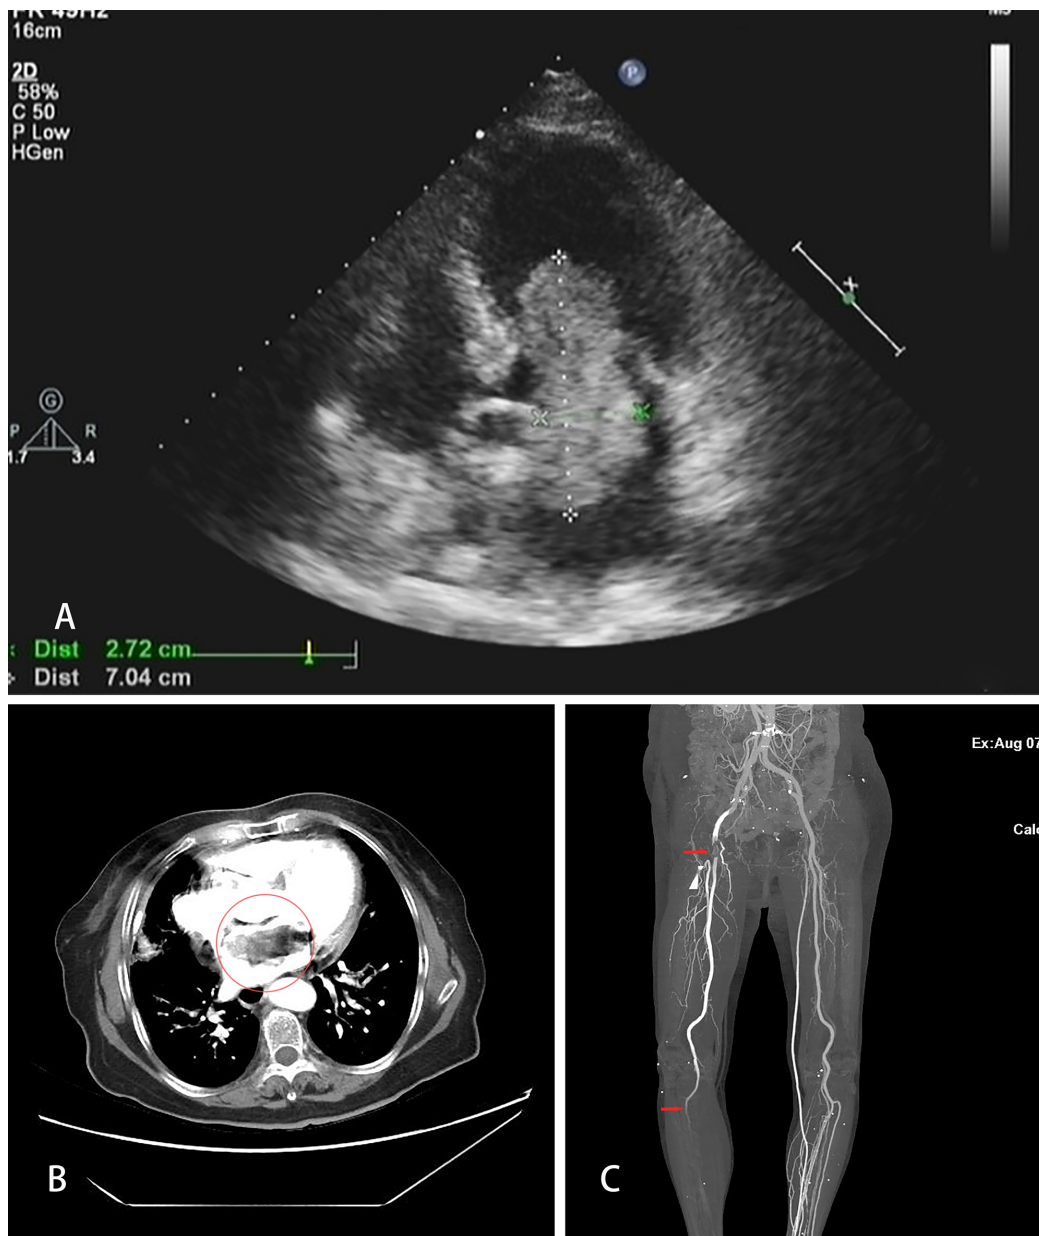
Echocardiogram and CTA imaging examination. (A) Transthoracic echocardiogram shows an atrial myxoma. (B) CTA shows an atrial myxoma. (C) CTA shows right lower limb artery embolism. CTA, computed tomography angiography.
